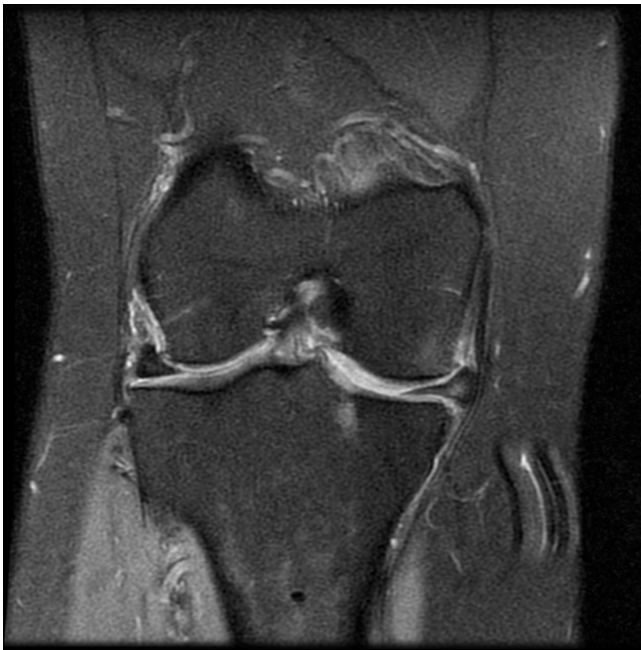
Coronal MRI radiograph following the surgical repair of a meniscal root tear demonstrating persistent meniscal extrusion. The extrusion depicted here is observably significant, measuring greater than 3 mm. This repair underwent subsequent revision.
